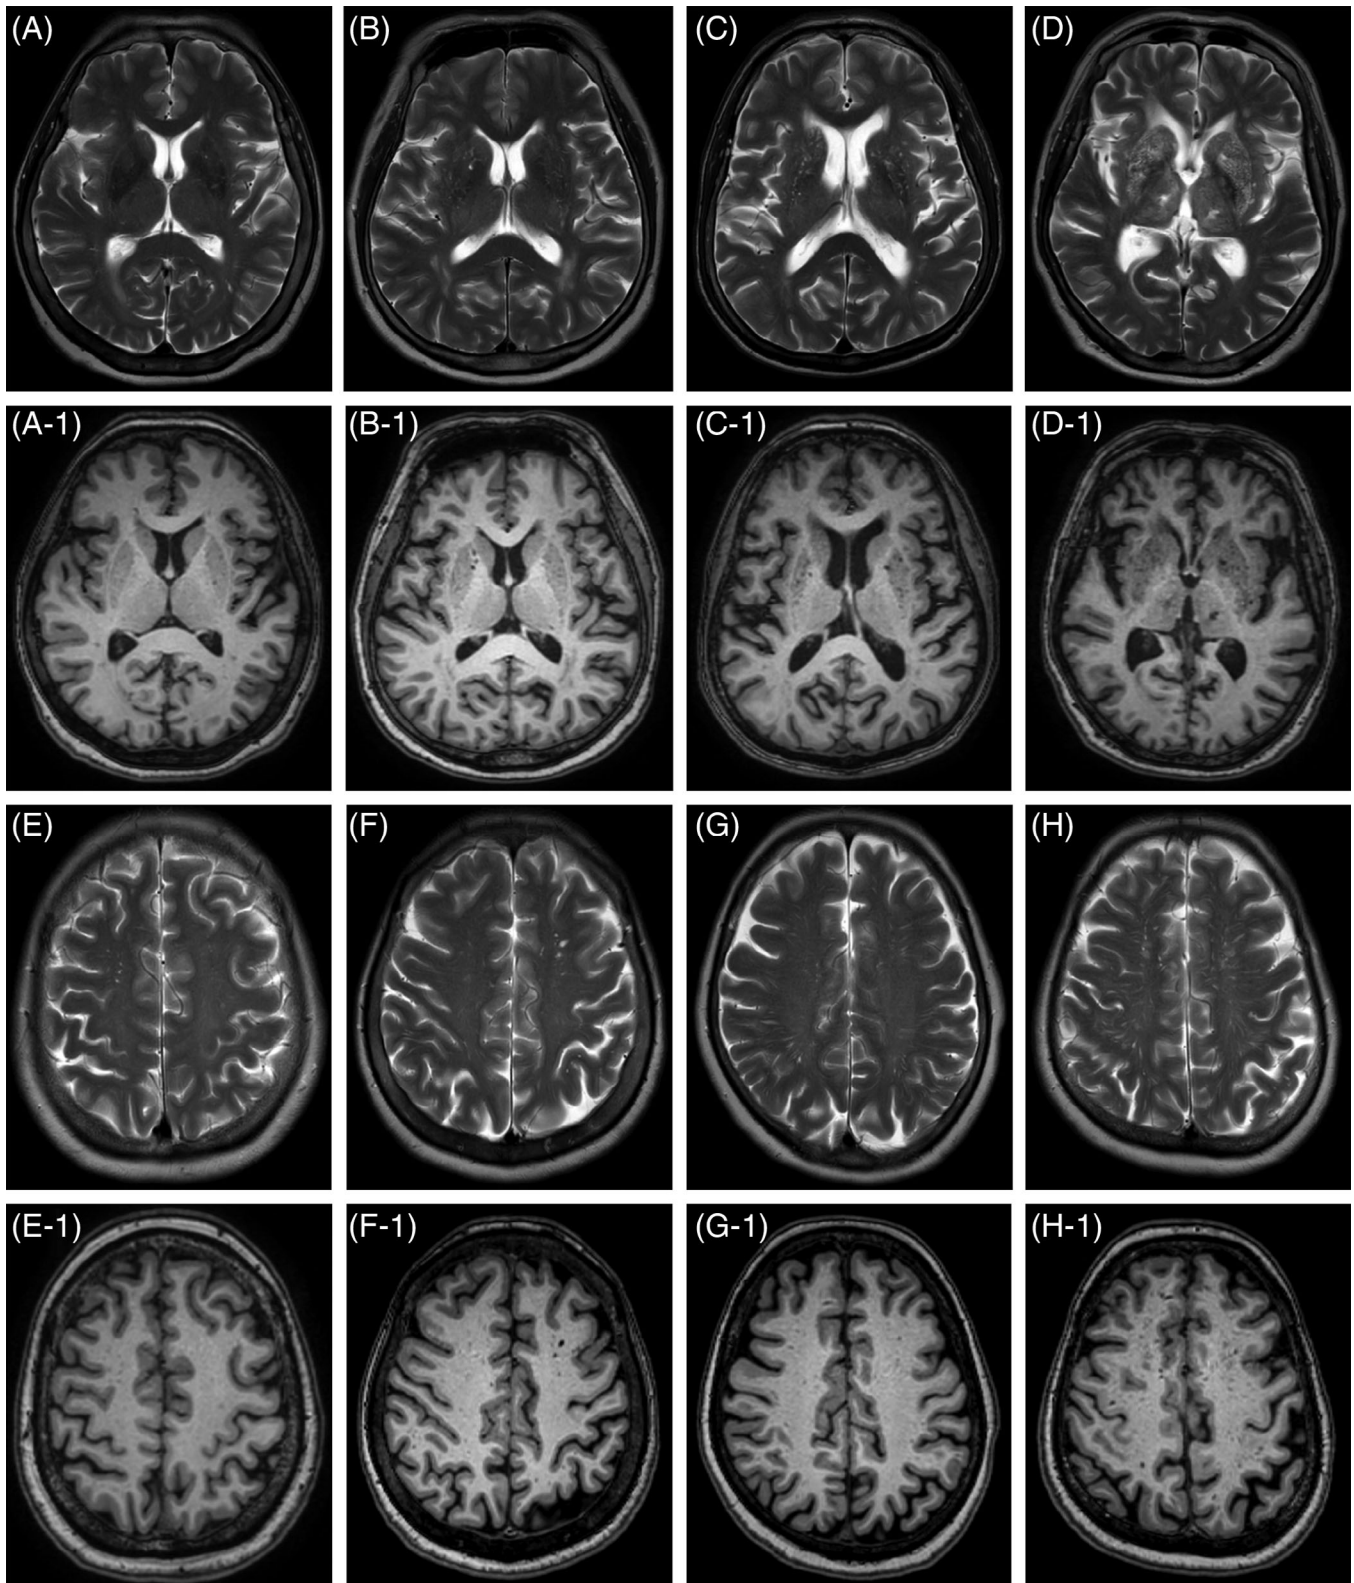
Example images of various grades of enlarged perivascular spaces by brain topography. (A–D) are images of basal ganglia: (A) Grade I (1–10 EPVS counts), (B) Grade II (11–20 EPVS counts), (C) Grade III (21–40 EPVS counts), (D) Grade IV (>40 EPVS counts). E–H are images of centrum semiovale. (E) Grade I (1–10 EPVS counts), (F) Grade II (11–20 EPVS counts), (G) Grade III (21–40 EPVS counts), (H) Grade IV (>40 EPVS counts). EPVS were assessed on the axial T2-weighted sequence. A-1-H-1, axial T1-weighted sequence; A-H, axial T2-weighted sequence; EPVS, enlarged perivascular space.
